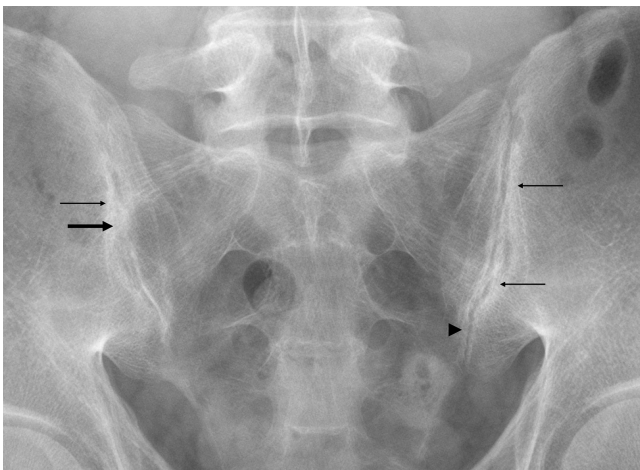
Radiograph (A) and magnetic resonance imaging in a T1-weighted sequence (B) of sacroiliac joints (SIJ) of a 42-year-old patient with advanced ankylosing spondylitis. A: definite subchondral sclerosis (thin arrows), partial ankylosis of right SIJ (thick arrow), narrowing of left joint space and localized area of small erosions (arrowhead) are visible. Scores for right SIJ: erosions 0, subchondral sclerosis 2, joint space change 4, sacroiliitis grade 3; left SIJ: erosions 2, subchondral sclerosis 2, joint space change 3, sacroiliitis grade 3. B: partial ankylosis of right SIJ is clearly visible, while joint space narrowing on the left side and subchondral sclerosis are not clearly visible. A number of small erosions in the left SIJ (arrowhead) were also found. Scores for right SIJ: erosions 0, subchondral sclerosis 1, joint space change 4, sacroiliitis grade 3; left SIJ: erosions 3, subchondral sclerosis 0, joint space change 1, sacroiliitis grade 2.
